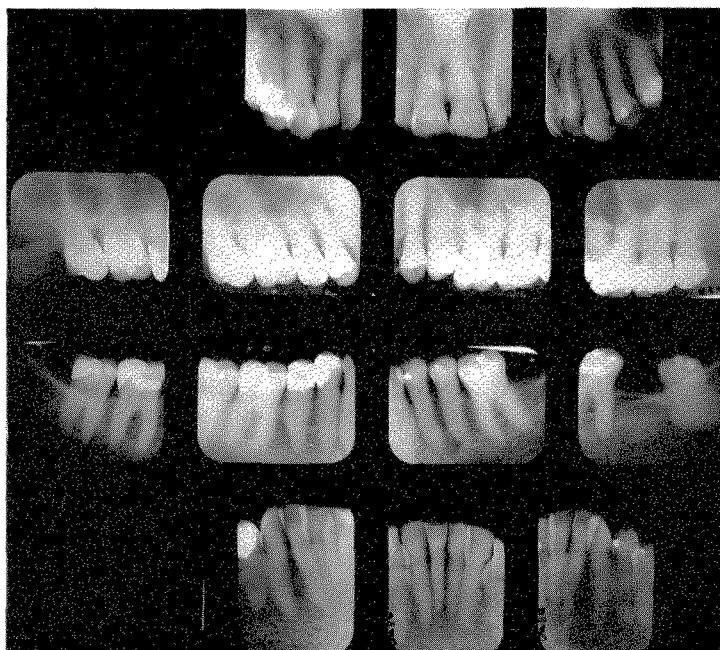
Roentgenograms taken in June, 1961, showing excellent structures in spite of the deep overbite, malocclusion, and missing teeth. The teeth of this patient are shown in Fig. 622.
